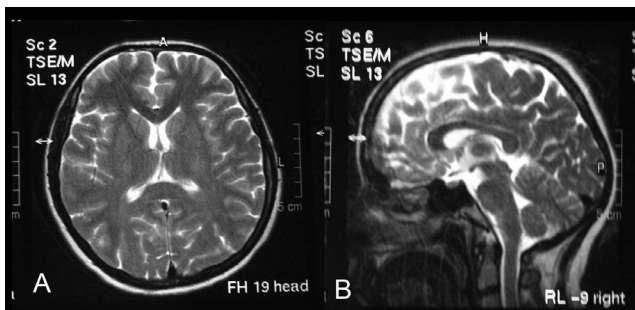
Transverse (a) and sagittal (b) T2-weighted image showing normal cranial MR findings
